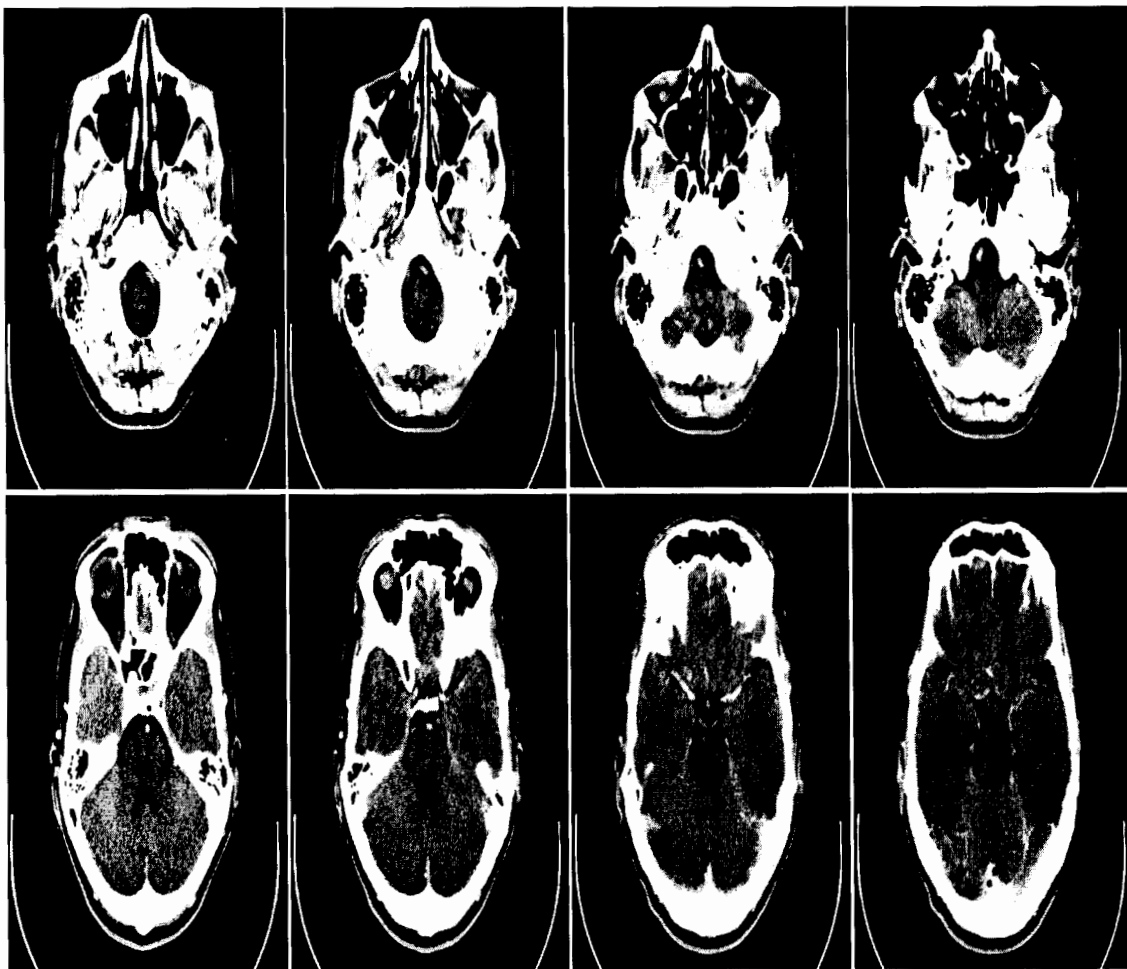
Computed tomography scan images.
